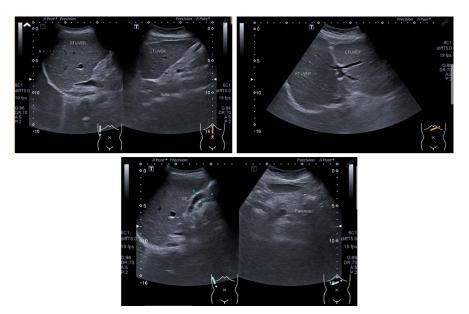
Normal ultrasonographic appearance
